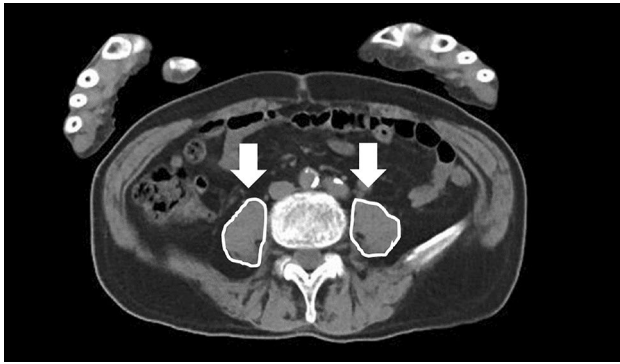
The measurement of psoas major muscle area (PMA). PMA (white arrow) at the fourth lumbar vertebra level was measured by CT
